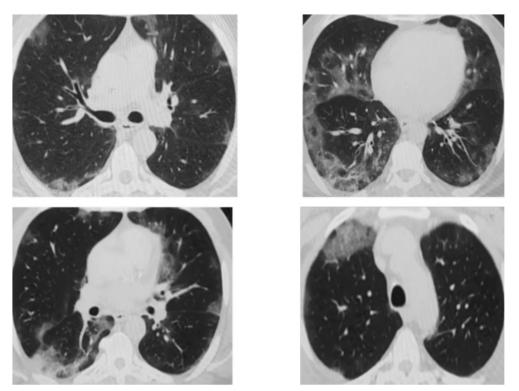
32 male patient complainting of fever and cough, Axial CT chest parenchymal window, Ground glass opacities seen in all images, the opacities are seen more peripherally.
